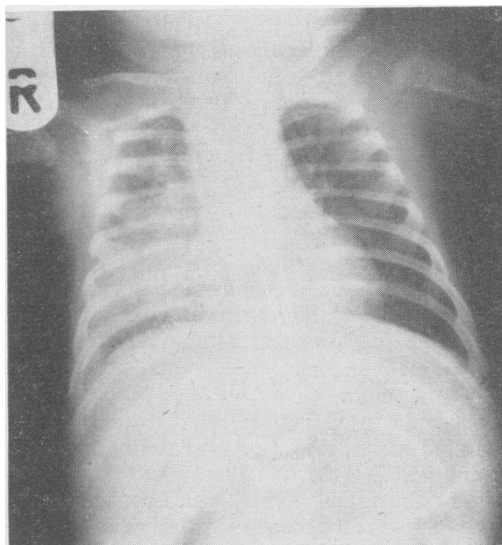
Age 6 weeks: Chest X-ray showing impaired translucency in right mid-zone.
